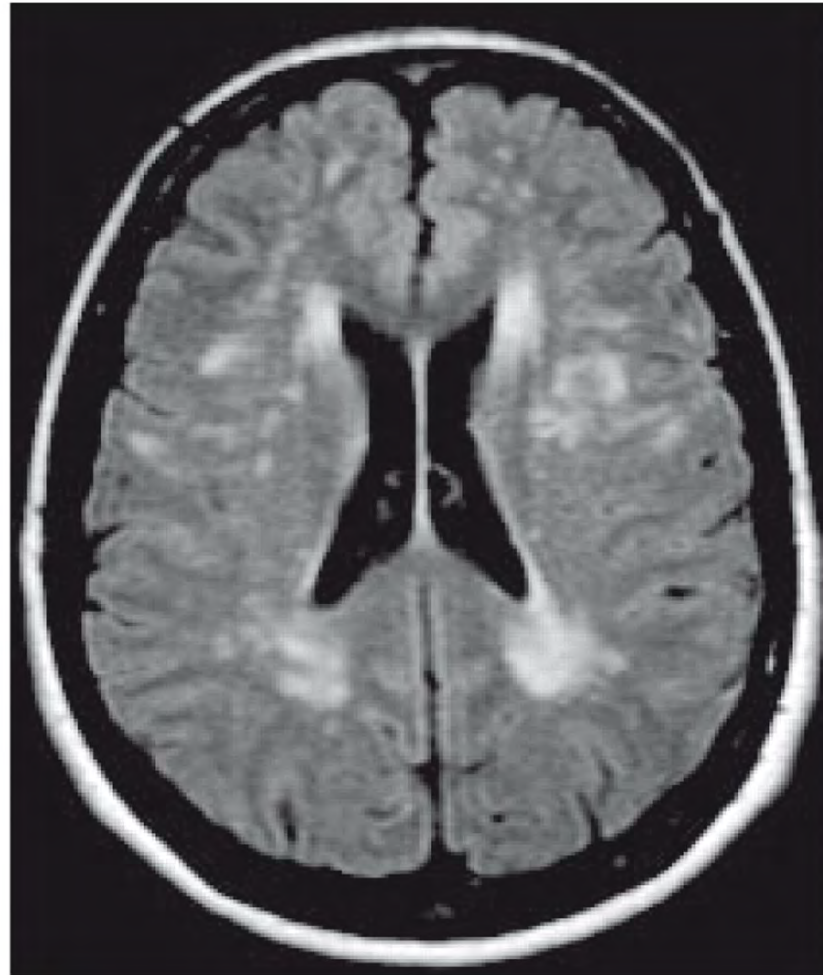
MRI scan of CADASIL.
